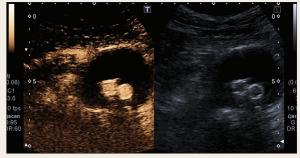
Axial view with contrast-enhanced ultrasound of the AAA with patent limbs and sac thrombosis at 6-month follow-up.
